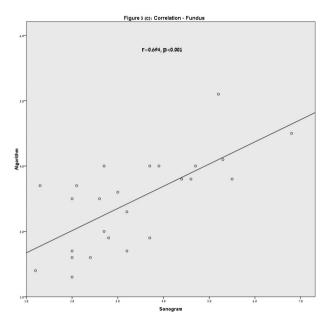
Correlations between the sonogram and the algorithm measurements of the fundus.
